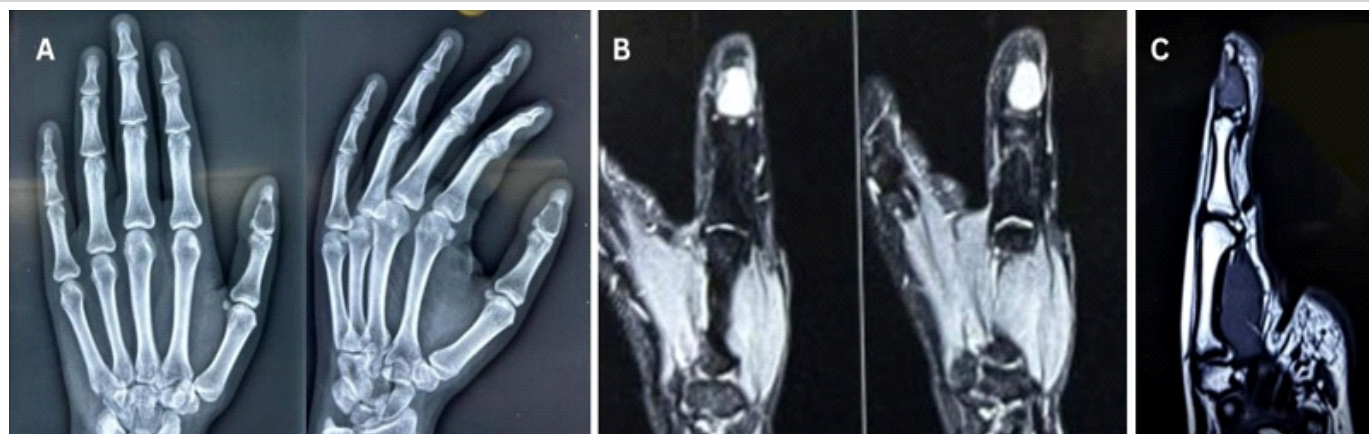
Pre-operative radiology, (a) plain radiograph showing a lytic lesion in the distal phalanx of the thumb. (b) T2-weighted image showing a hyperintense, well-circumscribed, geographic lesion without any marrow edema, consistent with enchondroma. (c) T1-weighted image showing a well-circumscribed hypointense lesion replacing the normal marrow in the distal phalanx of the thumb, suggestive of enchondroma.
